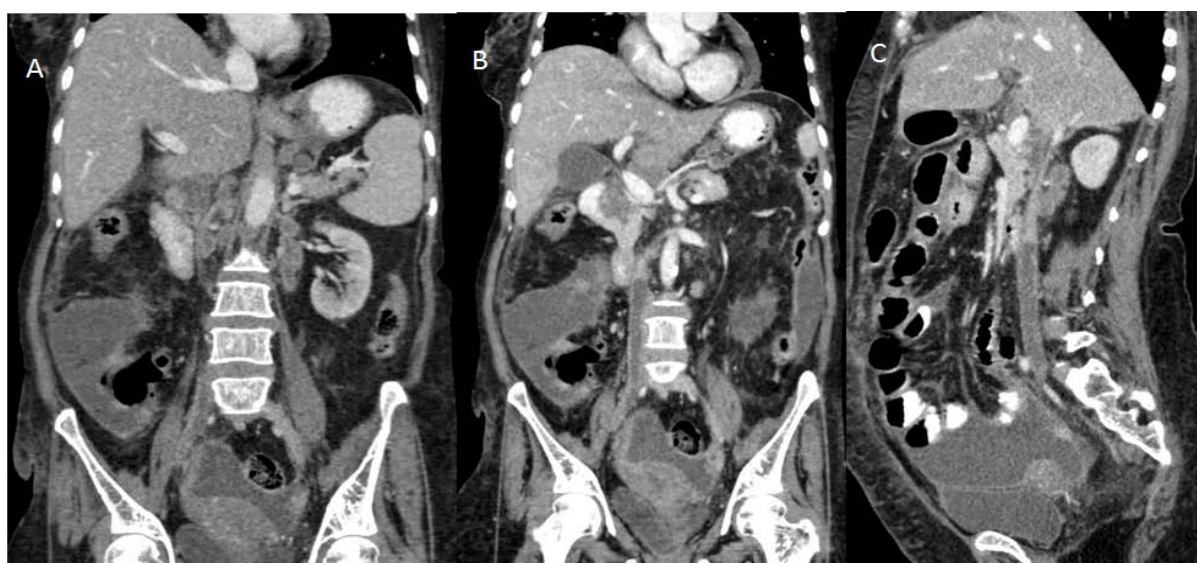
Contrast-enhanced CT scan of the abdomen (Coronal-A,B) and sagittal (C)-showing lymph nodes in left para-aortic, interaortocaval and precaval regions (A) with thrombosis in IVC extending right common iliac vein (B,C)
